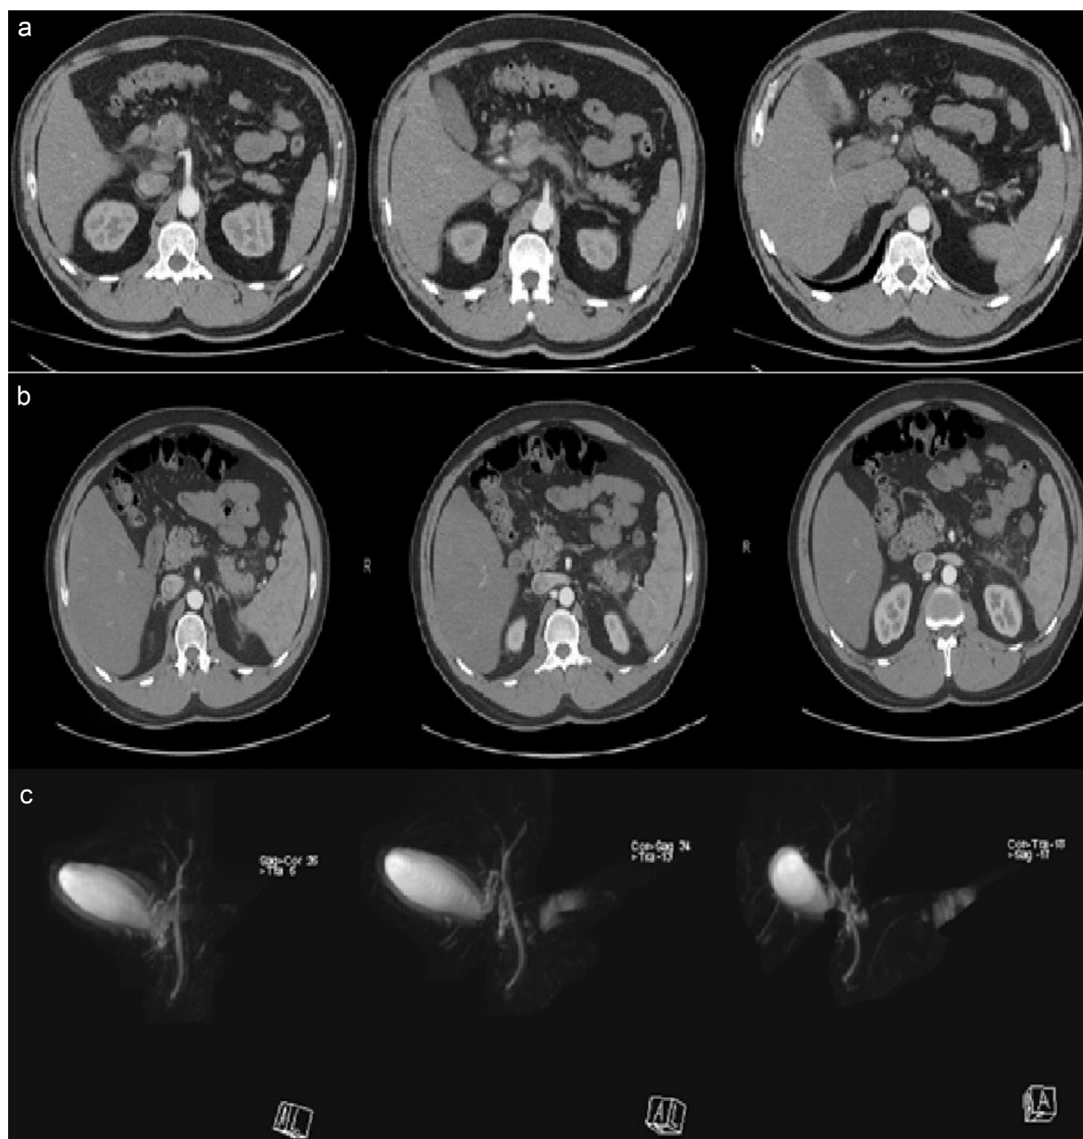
a). A contrast enhanced abdominal CT showed acute inflammation of pancreas and peripancreatic fat. b). Abdominal CT showed acute inflammation of pancreatic tail and peripancreatic fat without necrosis or free fluid. c). MRCP revealed normal findings of gall bladder, biliary tract and common bile duct.
